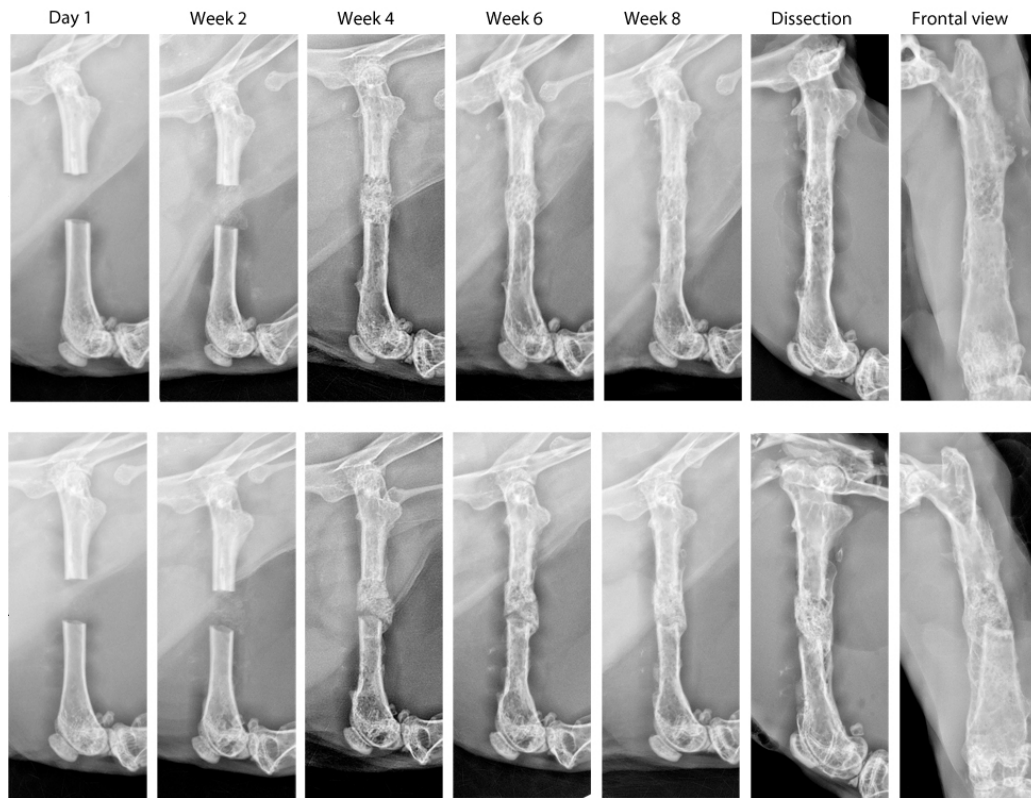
Radiographic progression of two long bone defects filled with collagen-HA scaffolds and culture expanded BMSCs.
